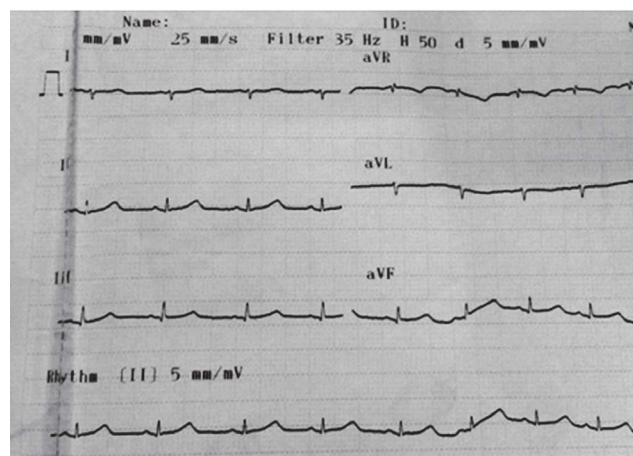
Echocardiogram at the first day of hospitalization
